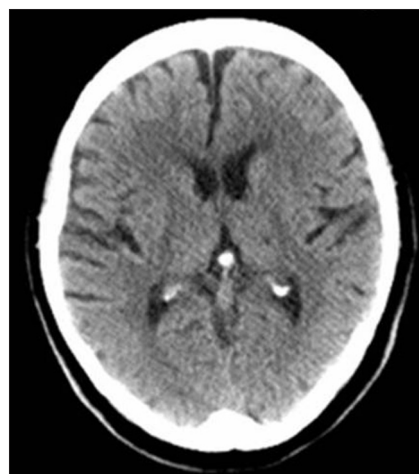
Computed tomography scan of the head shows no significant lesions.
